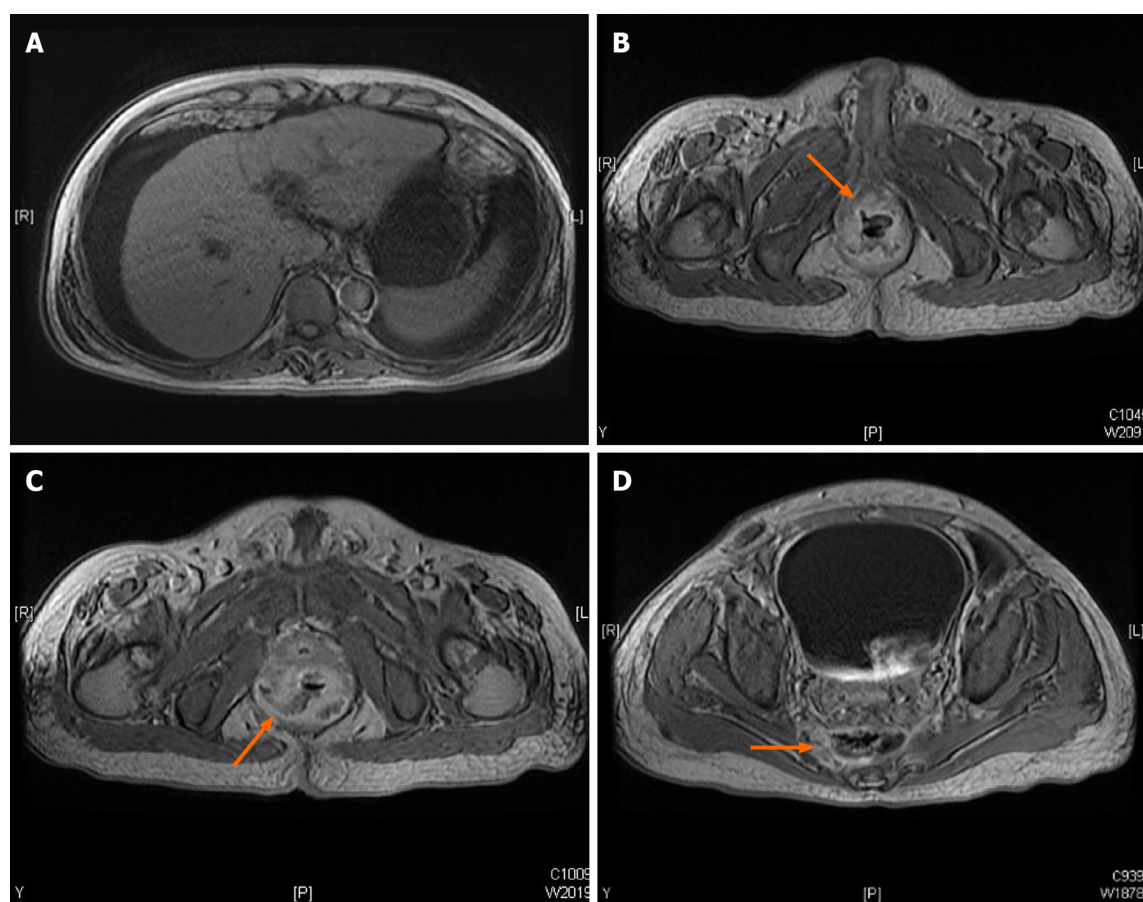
Magnetic resonance imaging at diagnosis. A: Liver cirrhosis with ascites; B: Rectoprostatic fistula; C: Rectopresacral fistula; D: Presacral abscess.
